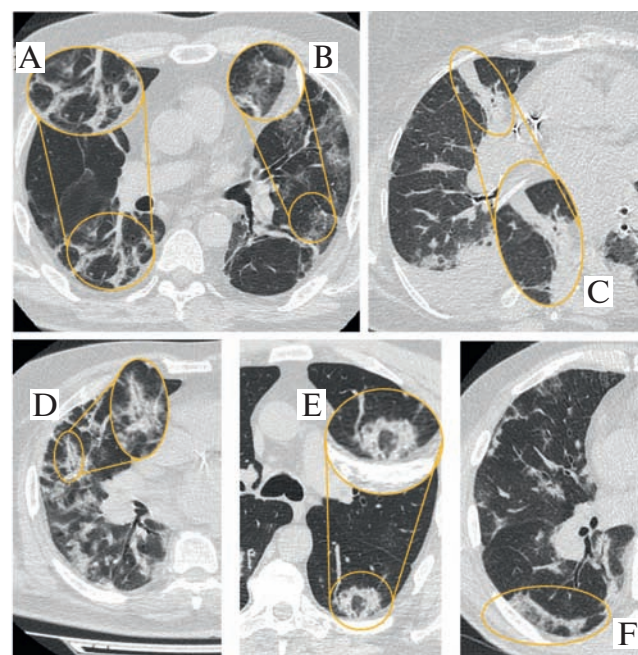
Common computed tomography signs of organizing pneumonia: A, perilobular reticular pattern; B, reticulation; C, linear consolidation; D, peribronchovascular consolidation; E, atoll sign (reversed halo sign); F, fibrous band parallel to pleura
